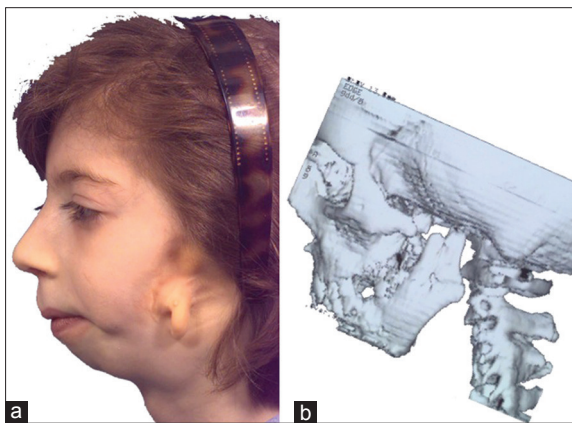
Pruzansky-Kaban Type IIa. The mandibular ramus, condyle, and temporomandibular joint are present but hypoplastic and abnormal in shape. The mouth can be symmetrically opened. (a) Profile view of the affected side in an adolescent girl; (b) three-dimensional (3D) reconstruction of a multi-slice computed tomography (CT) scan of the viscerocranium of the patient in a, demonstrating the abnormal shape and hypoplasia of the vertical ramus of the mandible
